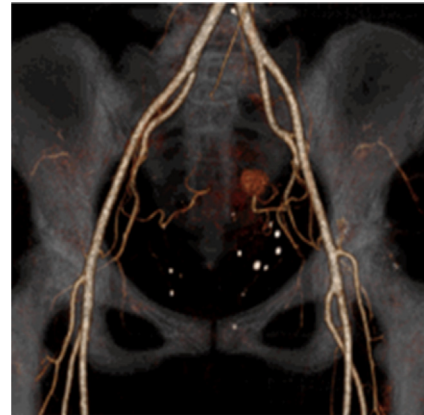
Three-dimensional computed tomography showing a pseudoaneurysm located at the distal end of the left uterine artery.
